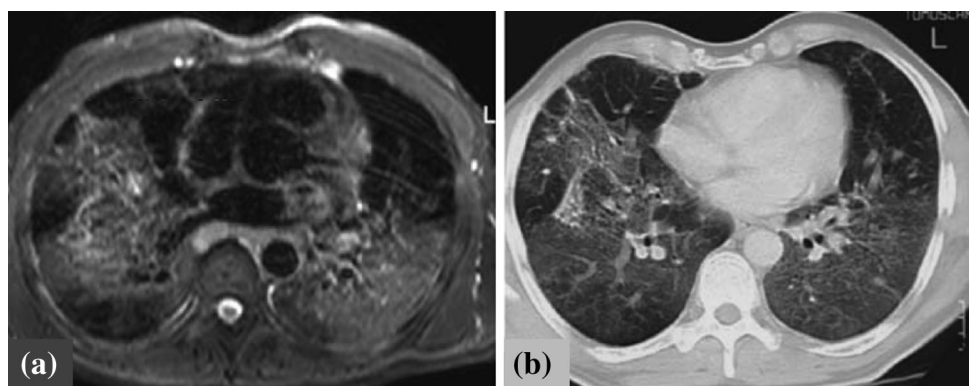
T2-weighted MRI (a) and (b) CT images of the thorax of the same patient showing the lack of similarity of the physical properties measured [29]. (With kind permission from Springer Science + Business Media)
